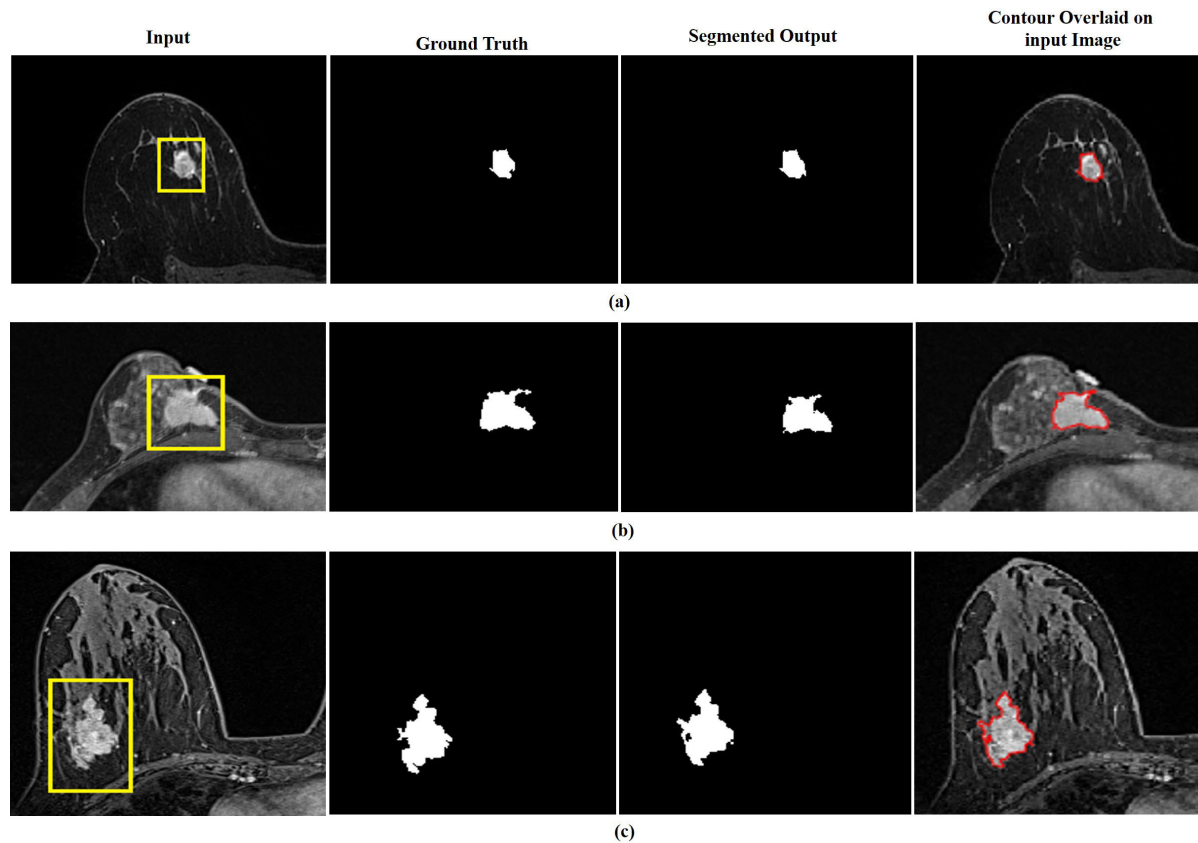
Representative axial DCE-MRI depicting grade-wise segmentation using CRBEO. (a) Grade 1, (b) Grade 2, (c) Grade 3.
